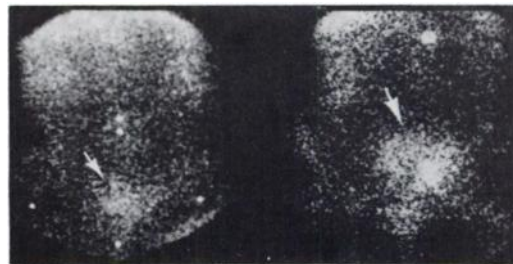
Early (6-hr, left) and delayed (24-hr, right) anterior ^{67}Ga scintigraphs in patient with diverticular abscess. In this instance abscess was more prominent on the delayed study.
